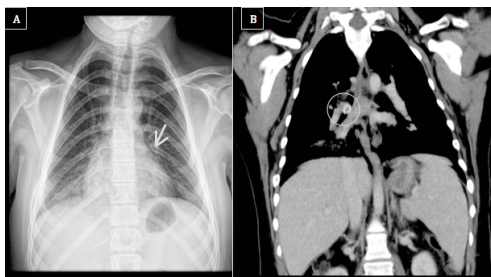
Radiological and Computed tomography findings
